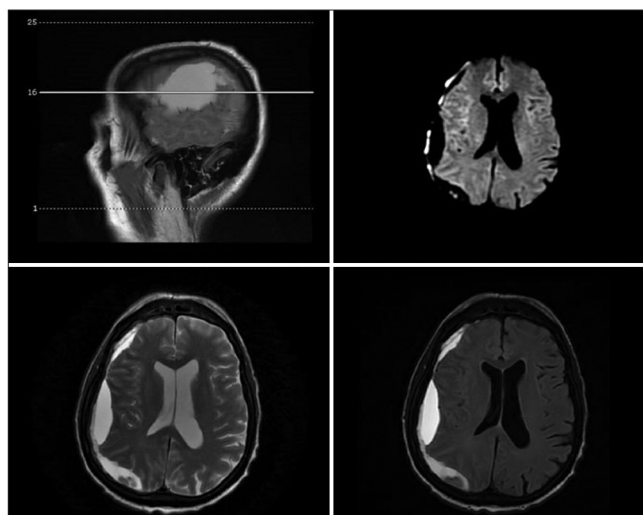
Head magnetic resonance imaging 54 days after initial presentation of subdural hematoma (SDH). Sagittal and axial views of the right-sided hyperintense with patchy hypointense areas consistent with acute on chronic SDH.
